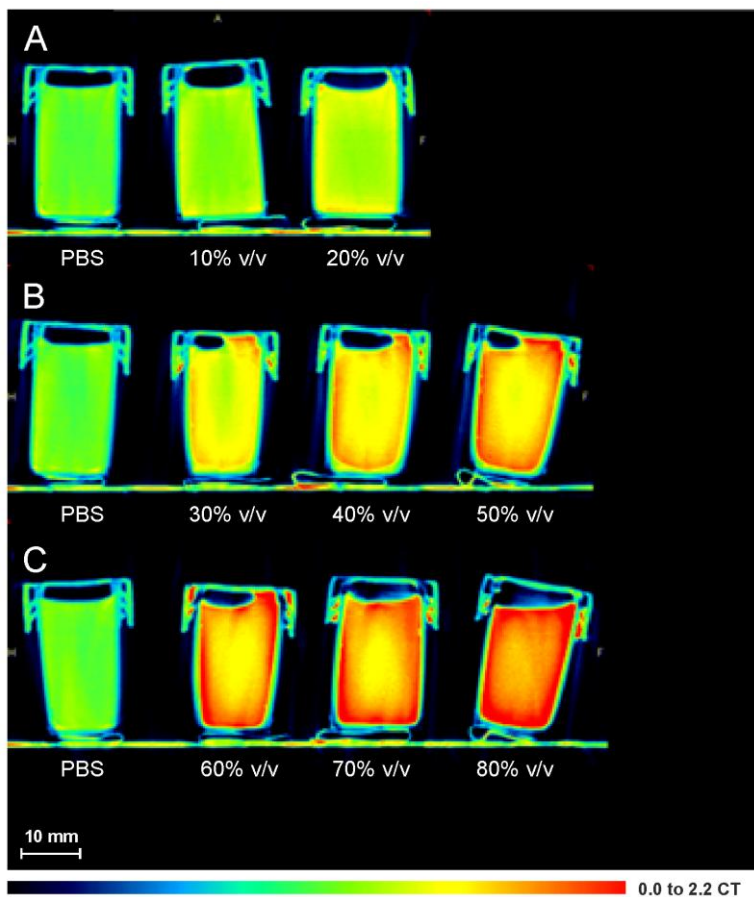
CT image of different Me_2SO solutions in PBS in 20 ml PP Falcon tubes, at 20 °C. The different solutions are, from left to right: (A) 0M (PBS), 10% v/v and 20% v/v Me_2SO , (B) 0M (PBS), 30% v/v, 40% v/v and 50% v/v Me_2SO and (C) 0M (PBS), 60% v/v, 70% v/v and 80% v/v Me_2SO . The CT image uses the cold scale and the spatial resolution is 200 μm
